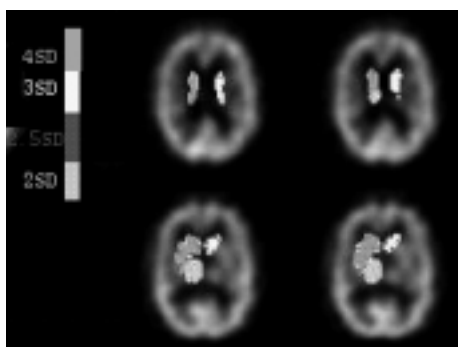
Quantified ECD SPECT eight months after stroke disclosing hypoperfusions in the thalamus, both caudate nuclei and the left lentiform nucleus.
